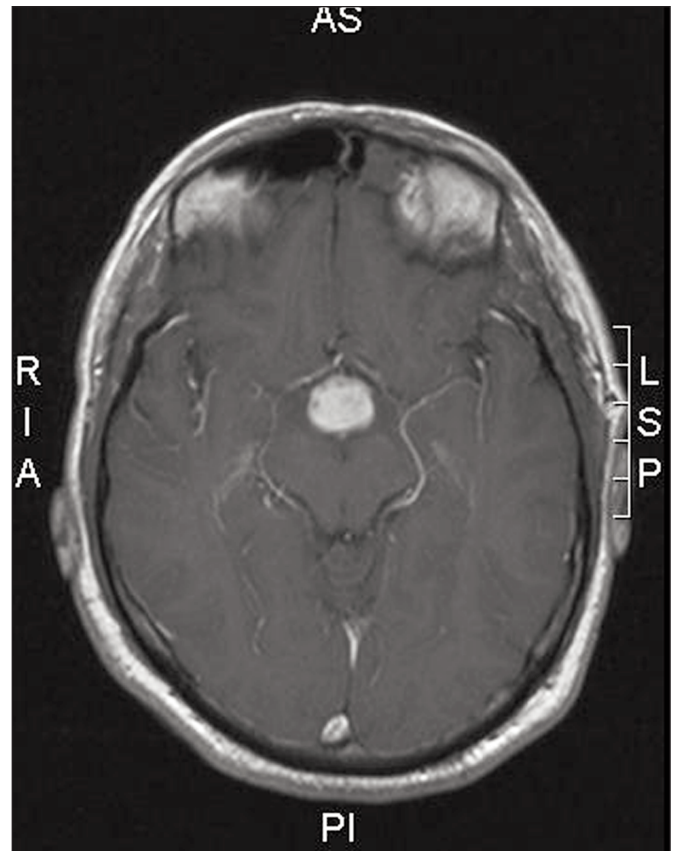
MRI T1 Axial post gadolinium.
